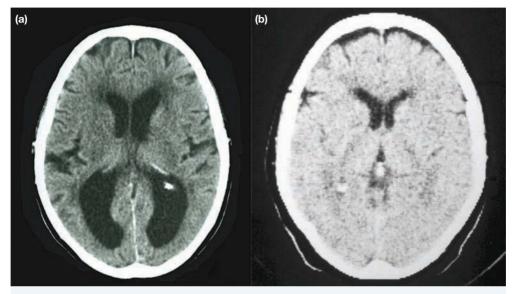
(a) CT scan of the brain of a person with Alzheimer's disease. Dead brain cells (neurons) produce a darker image then do healthy, living cells. Note the size of the black areas showing abnormal tissue compared to (b) the image of a healthy brain.
